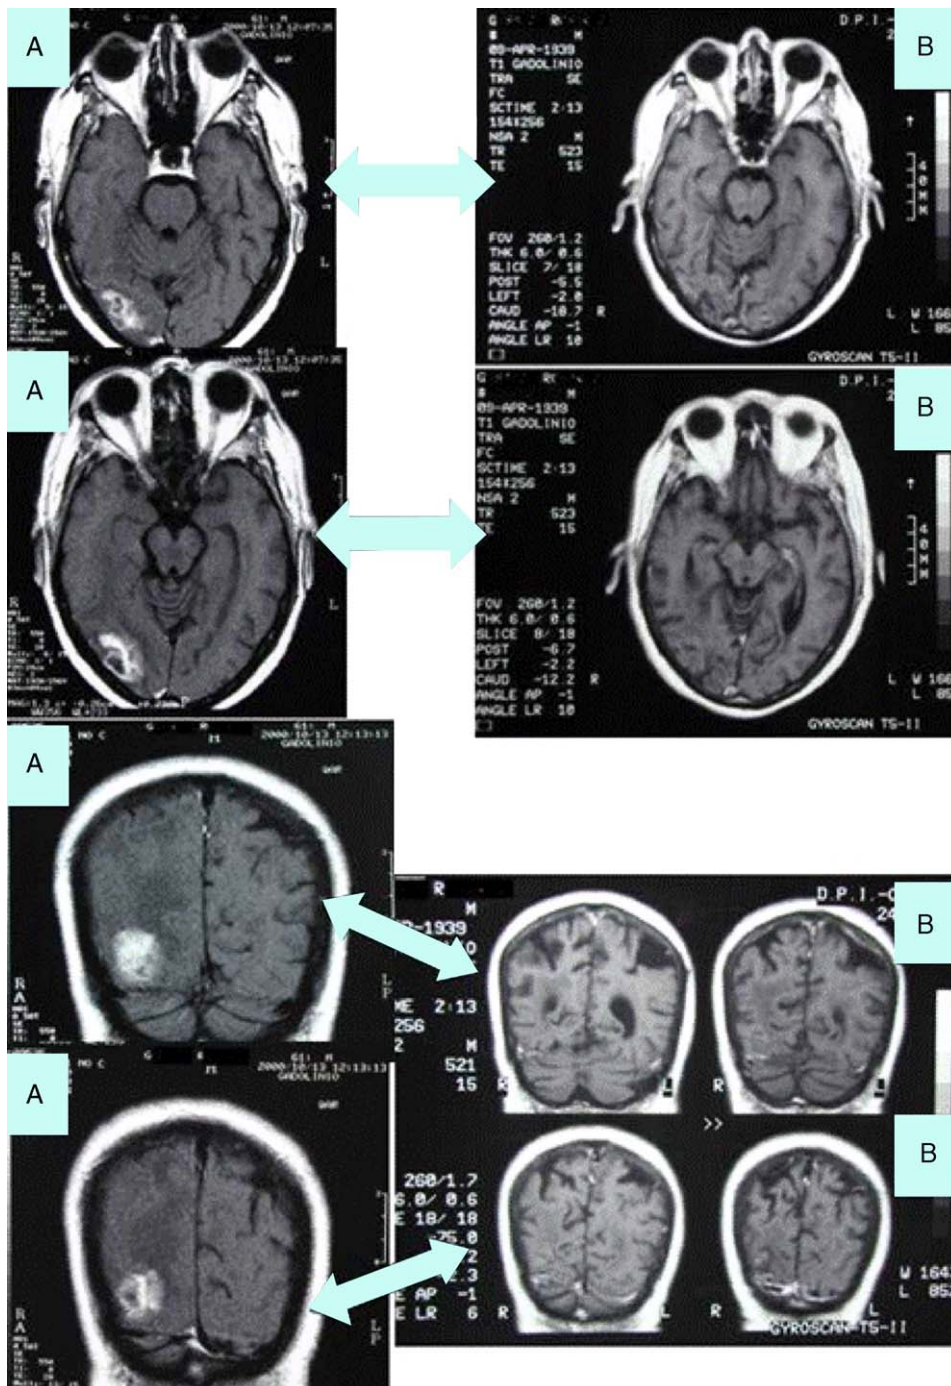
Magnetic resonance imaging of one metastatic brain lesion in the brain of a 60-year-old man with non-small cell lung cancer at baseline (6 months after end of WBRT) (A) and 40 months after the start of treatment with temozolomide (B). Persistent complete remission of brain disease.
